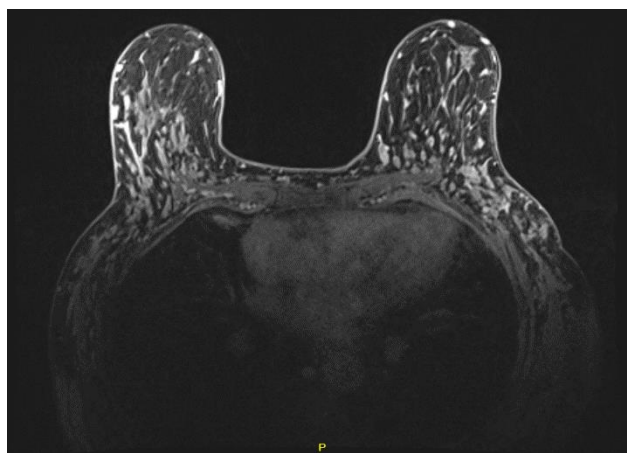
MRI axial breast.
